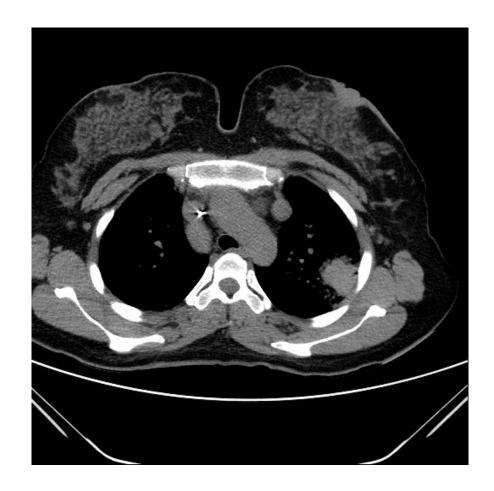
Chest CT showed non heterogeneous mass like lesion measuring $4 \times 5.2 \times 5.6$ cm in superior segment of inferior lobe of left lung.
